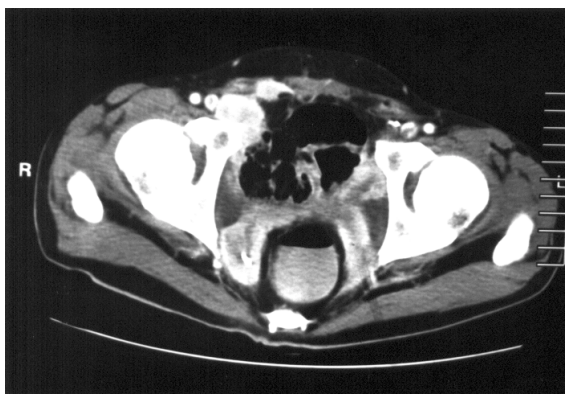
Enhanced CT of the pelvis taken at the same level as Fig. 6B shows significant reduction in the size of the tumour following further radiotherapy.
